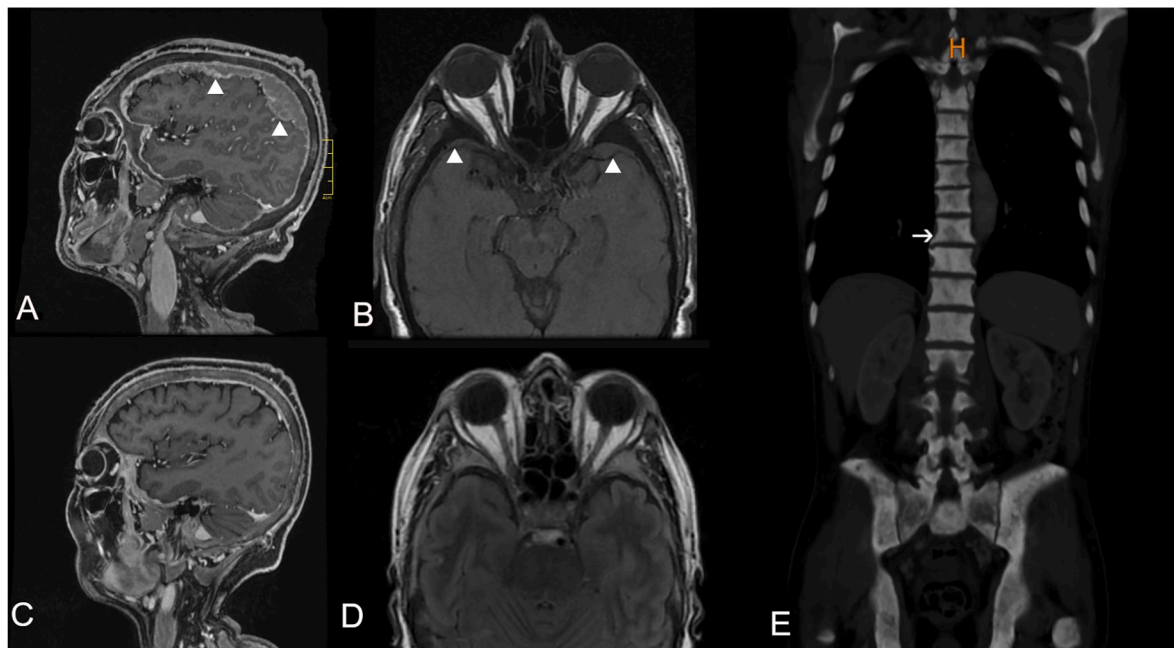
A: sagittal T1-weighted gadolinium-enhanced brain magnetic resonance imaging (MRI) showing diffuse and nodular pachymeningeal metastatic thickening with peripheral gadolinium enhancement (arrowheads). B: horizontal T1-weighted brain MRI showing close relationship of both optic nerves with pachymeningeal metastatic involvement (arrowheads). C: sagittal T1-weighted gadolinium-enhanced brain MRI showing resolution of the diffuse and nodular pachymeningeal thickening described in Fig. 3A after initiation of specific oncologic treatment. D: horizontal T2-flair brain MRI showing good definition of both optic nerves after treatment. E: initial computed tomography scan of the thorax, abdomen and pelvis showing axial skeleton involvement; arrow pointing at one osteolytic lesion.
